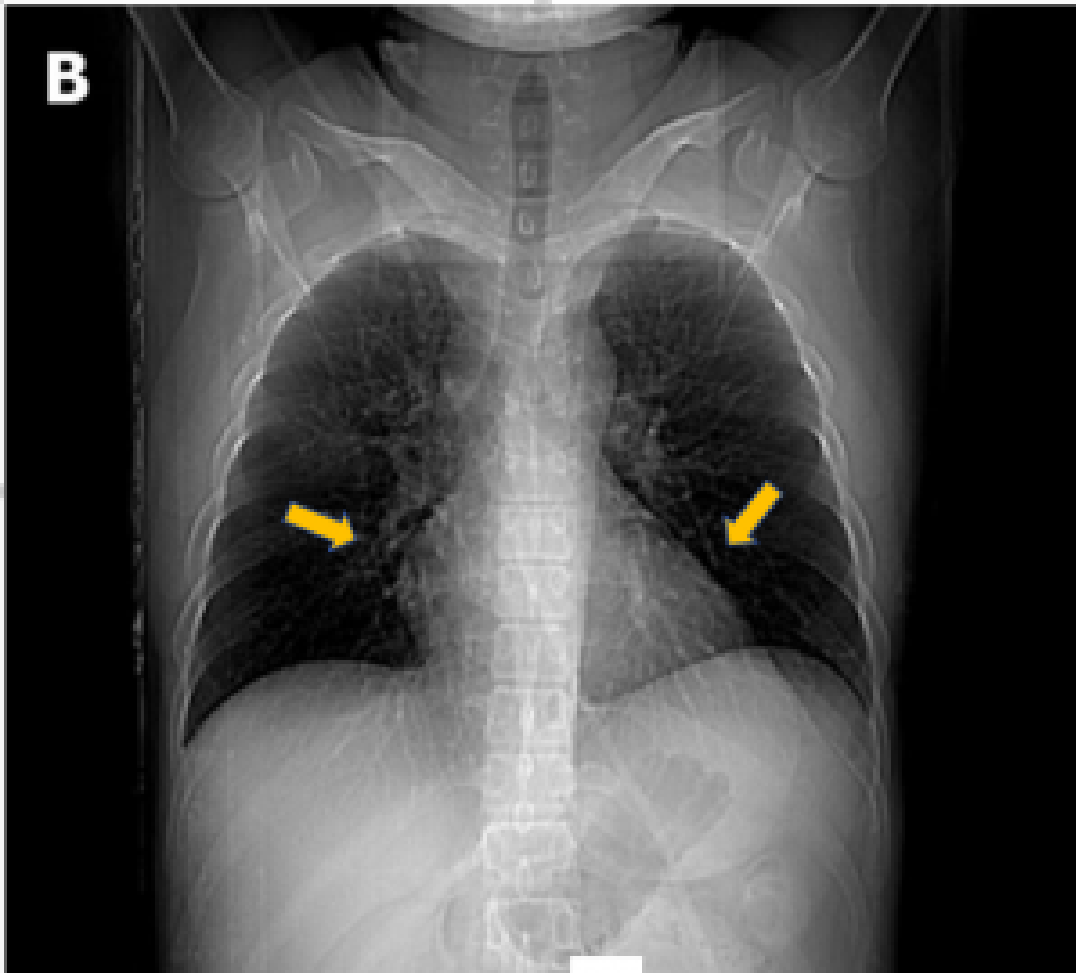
B. Multislice CT chest scan, showing little interstitial change (yellow arrows) in the lower lung.¹
